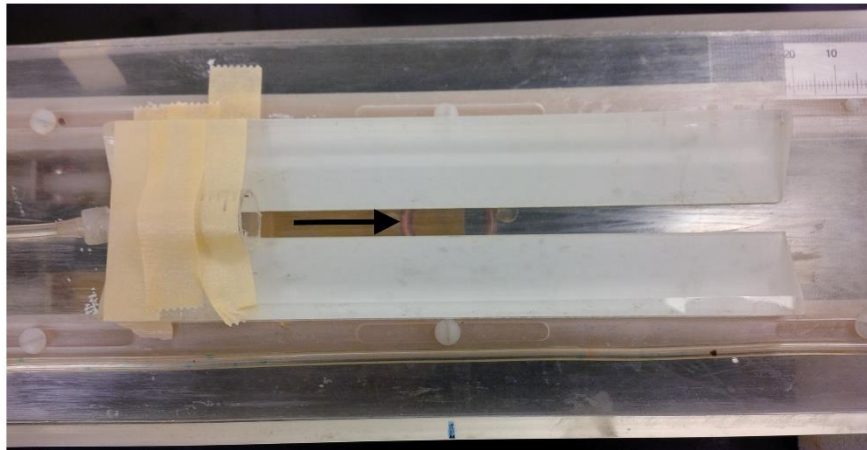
Surface coil and apparatus used for all MRI acquisitions. Images show the apparatus from a side view and from a top view. The surface coil itself is circular and is pointed out with the black arrow.
